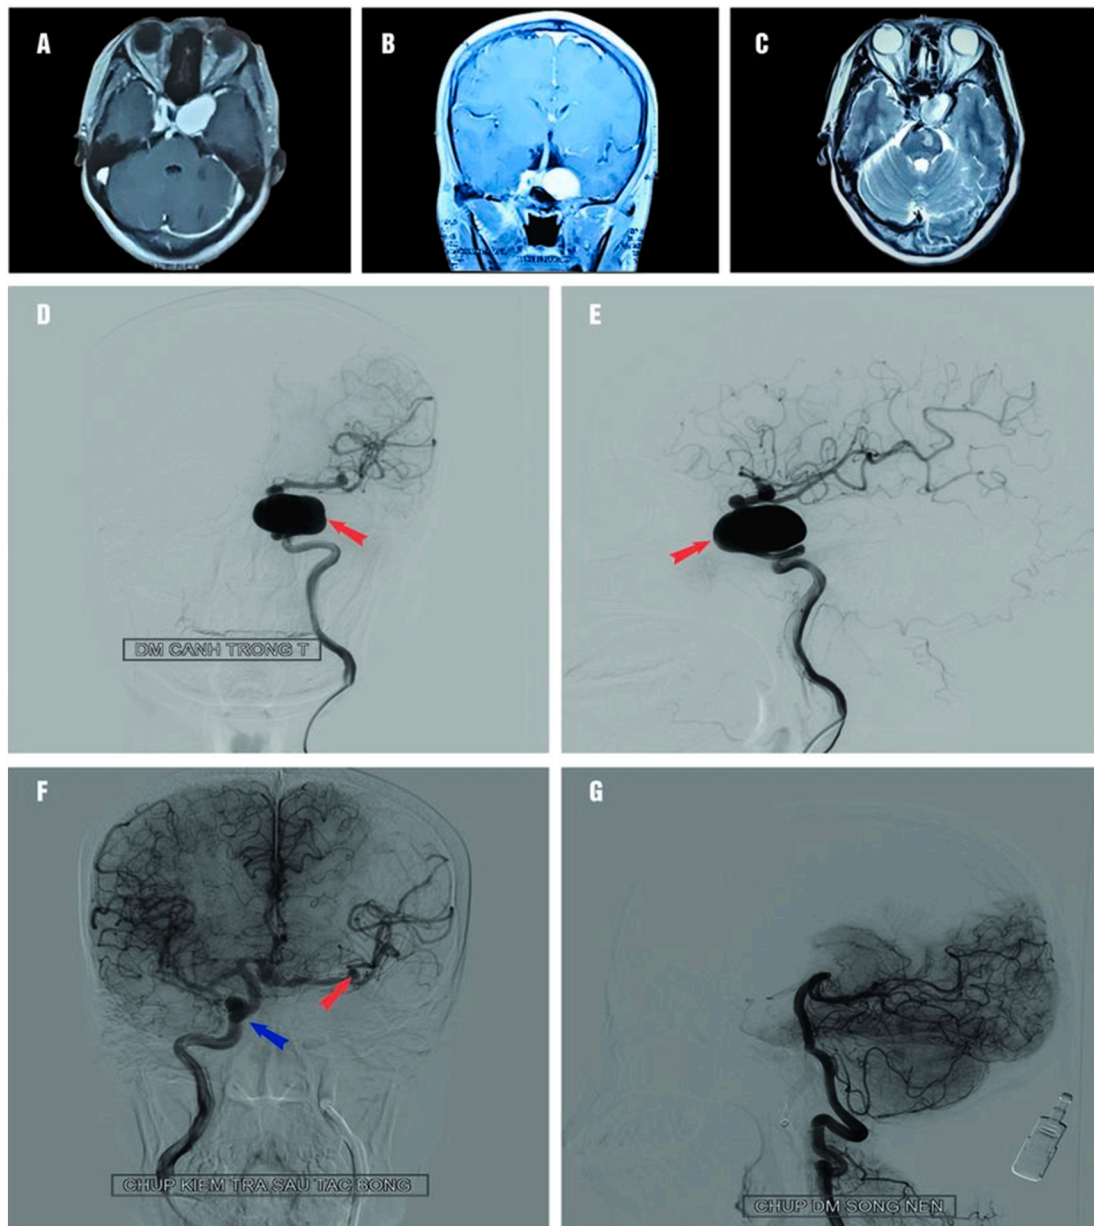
A, B: MRI demonstrated a heterogeneous lesion at the cavernous ICA with vivid enhancement after gadolinium injection. C: A T2 weighted image demonstrates the partially thrombosed aneurysm.
